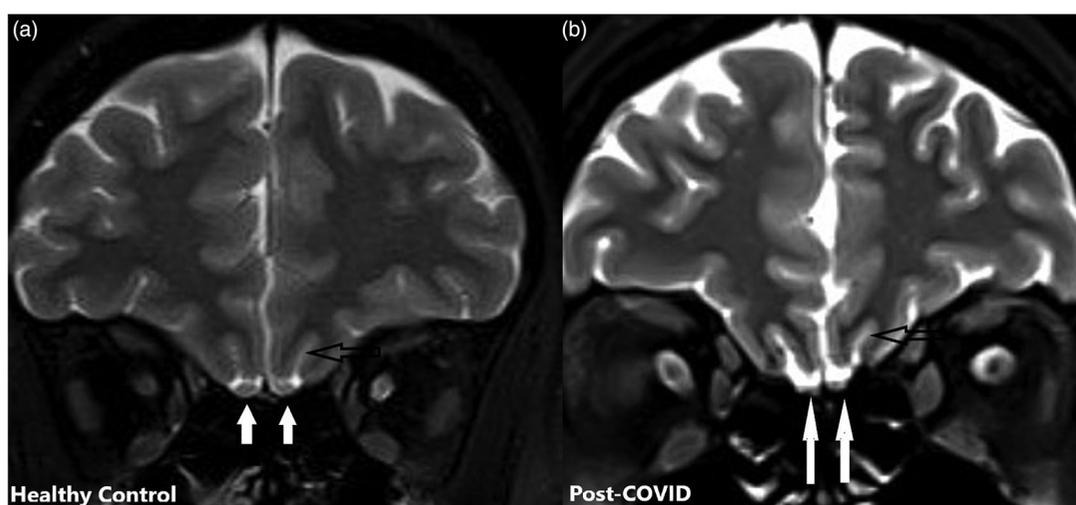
A healthy adult 39-year-old male case (a) and a 40-year-old male COVID-19 case (b) chronic period appearance, in fat-suppressed coronal T2-weighted images with 3 mm slice thickness. In the right image (b), there is a loss of volume in the olfactory bulb and an increase in CSF distances around the olfactory nerve (arrows). Also, note the shallowness of the olfactory sulcus in the picture (hollow arrow).
